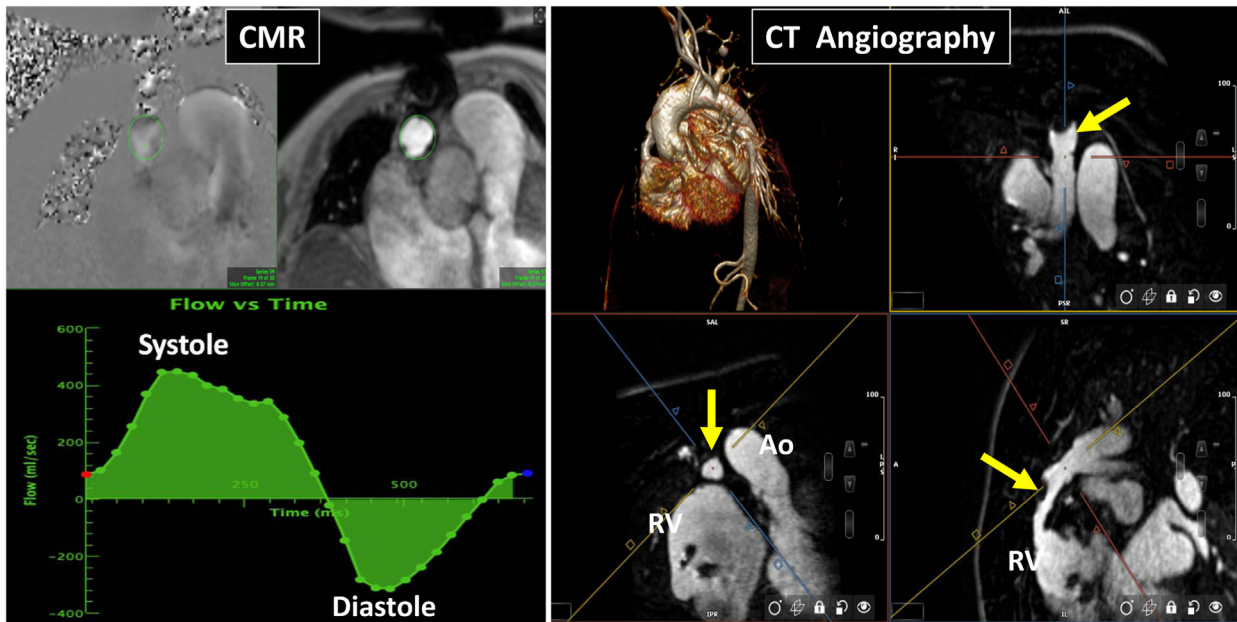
A case of tetralogy of Fallot with a 20-mm homograft placed 25 years earlier. CMR phase contrast systolic and diastolic flow (*left*) shows significant stenosis and regurgitation (4.1 m/sec, with a regurgitation fraction of 41%). Computed tomographic angiography with multiplanar reconstruction (*panels*) shows stenosis of the homograft (14 × 15 mm) secondary to calcification. The *yellow arrows* point to the pulmonary homograft. Ao, Aorta; RV, right ventricle.
